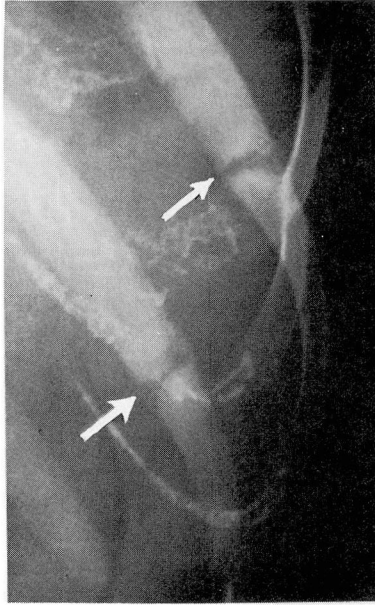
Roentgenogram of the tenth and eleventh ribs, showing Looser's lines in detail (arrows). Note the jagged and slightly sclerotic margins of the pseudofractures. There is no evidence of formation of callus.
